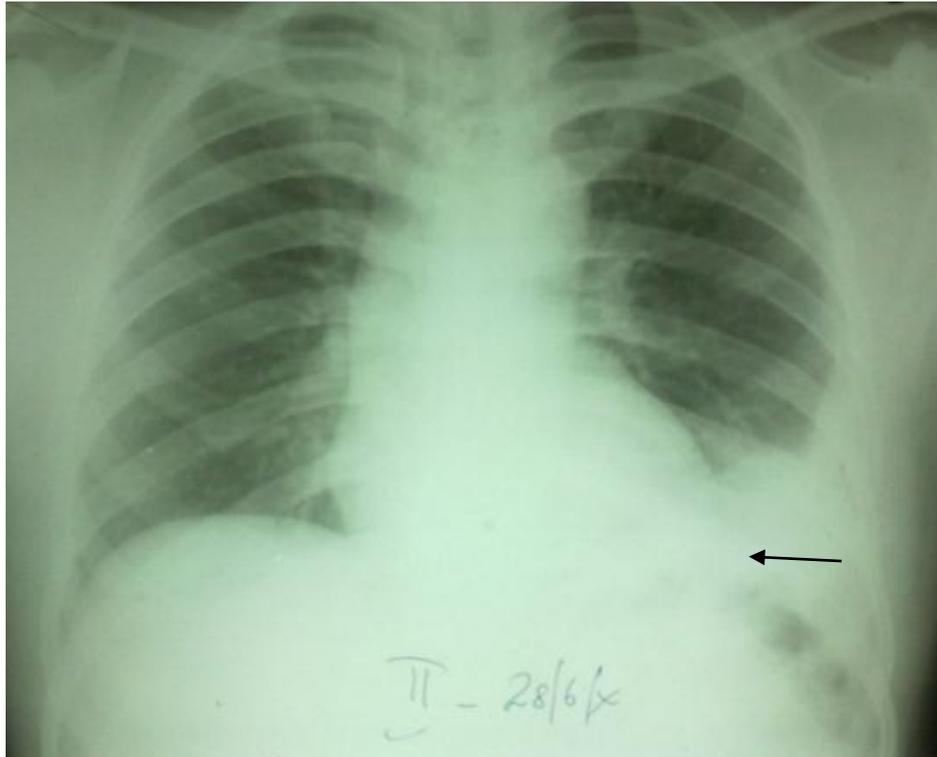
Pleural effusion (Chest Xray showing left lower Zone opacity mimicking Black arrow)
